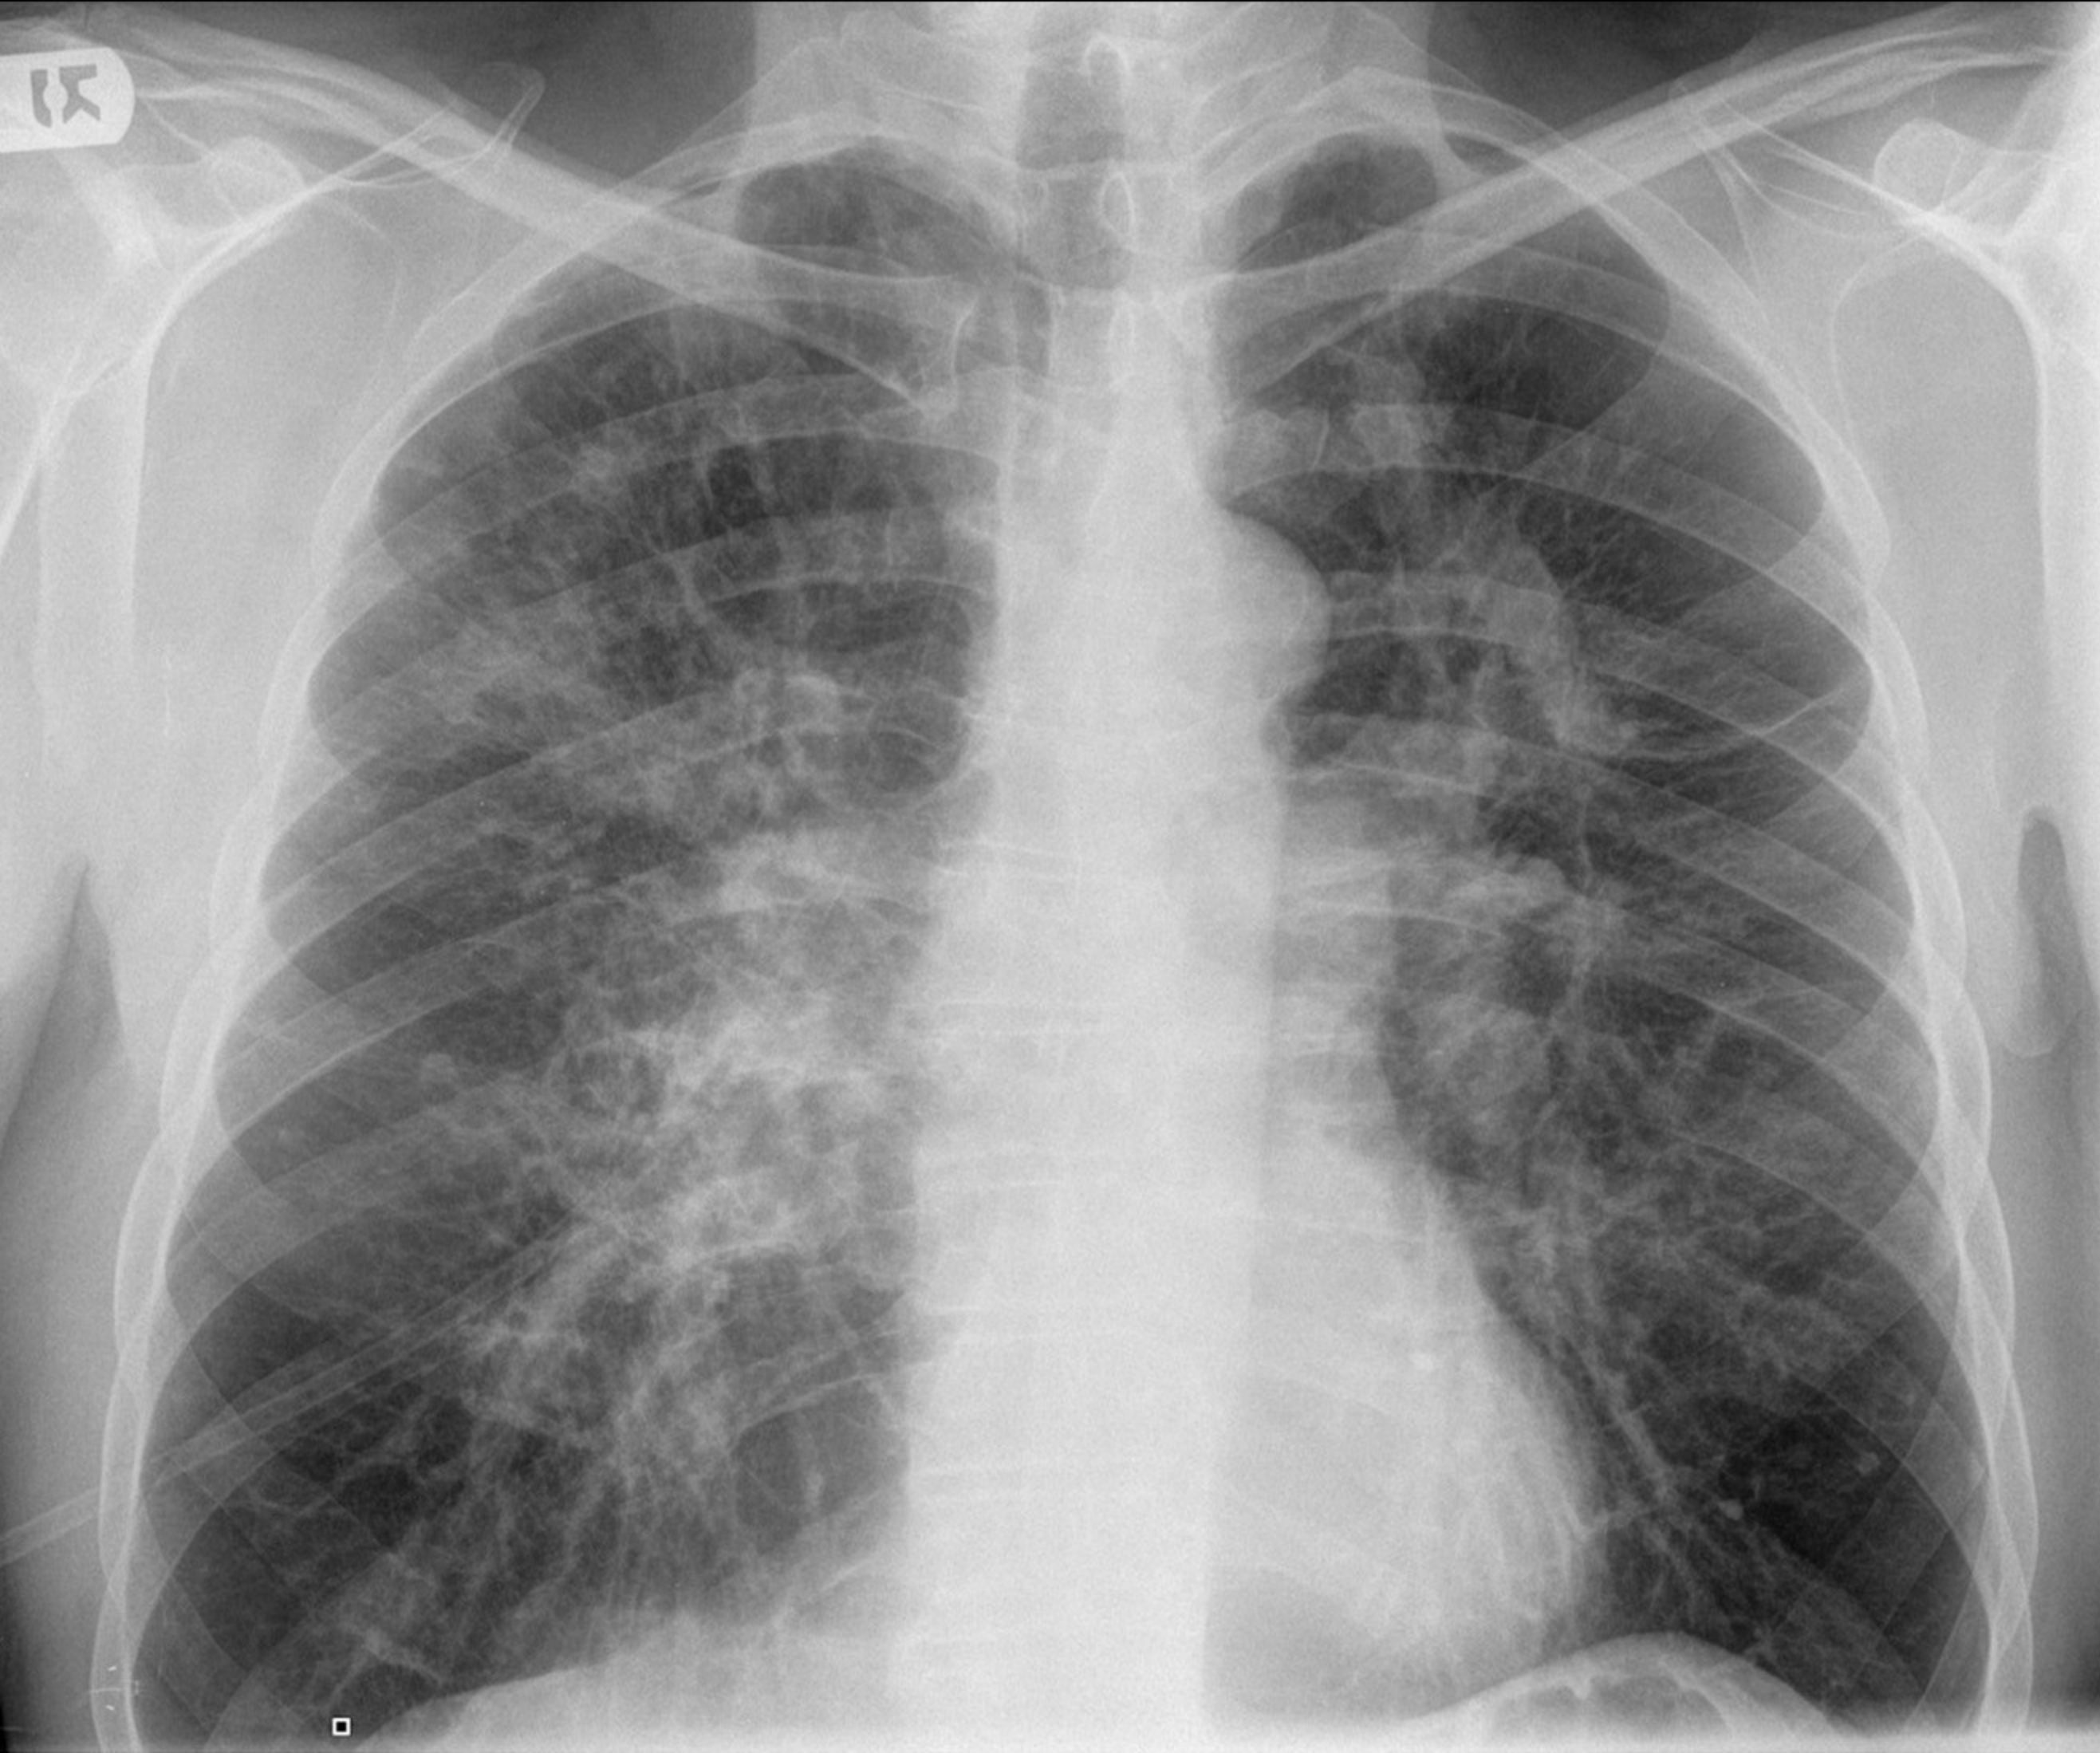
CXR and CT scan of chronic complicated silicosis, or progressive massive fibrosis (PMF) showing nodular lung lesions of one centimeter or greater in diameter, usually in the upper lung zones.
